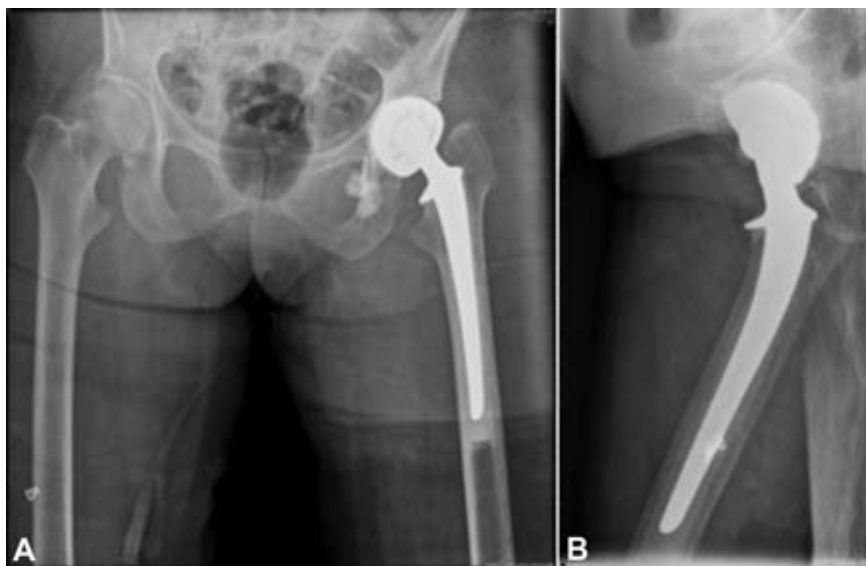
The antero-posterior (A) and lateral (B) views of the radiographs for the Avantagè dual mobility cup that dislocated. Note the extreme anteversion of the cup and the stem.
